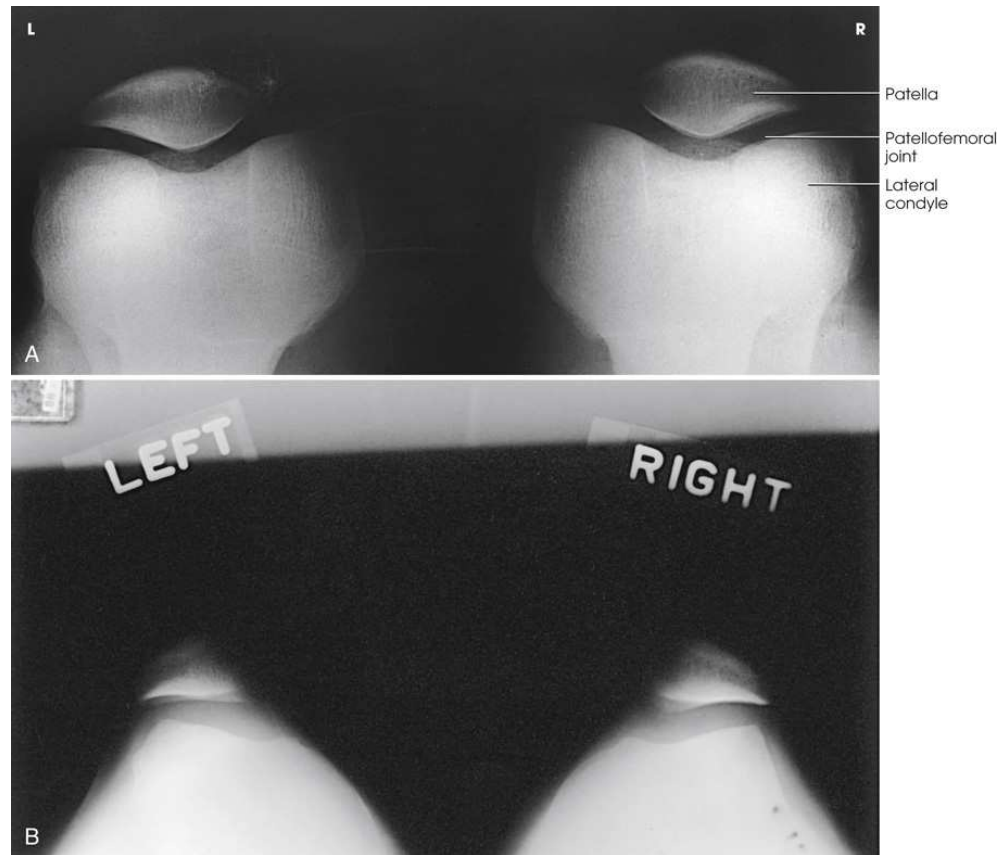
(A) Normal tangential radiograph of congruent patellofemoral joints, showing patellae to be well centered with normal trabecular pattern. (B) Abnormal tangential radiograph showing abnormally shallow intercondylar sulci, misshapen and laterally subluxated patellae, and incongruent patellofemoral joints (left worse than right). Courtesy Alan J. Merchant.
